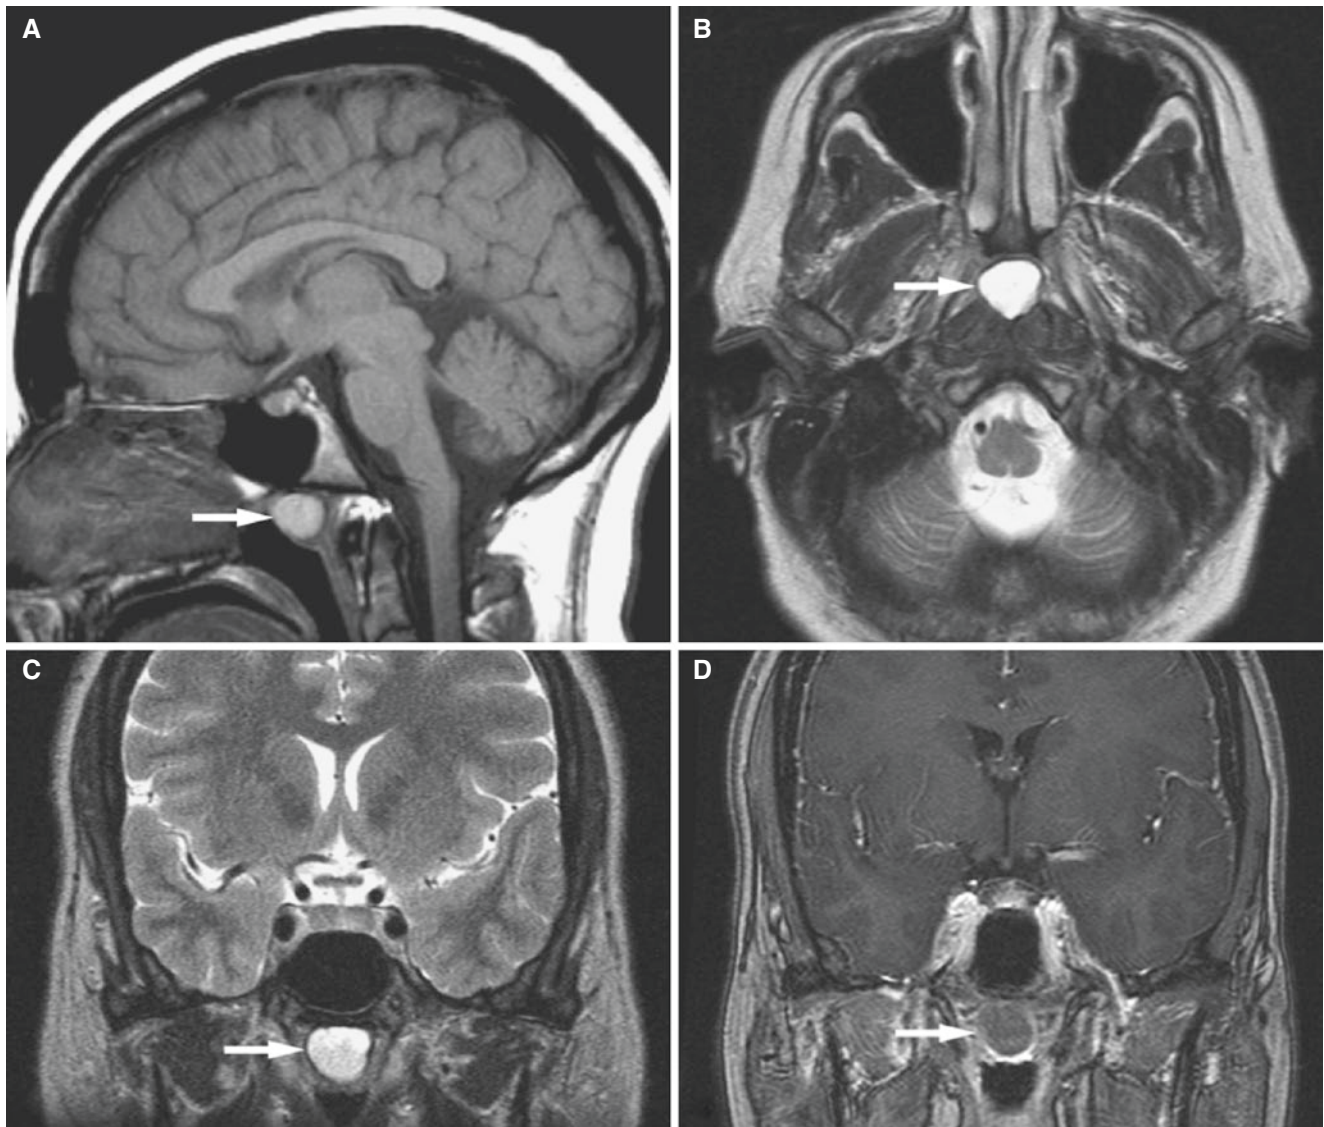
Tornwaldt's cyst, large; incidental findings in a 30-year-old. (A) Sagittal T1-weighted MRI shows low-signal cyst (*arrow*) in posterior nasopharynx. (B) Axial T2-weighted MRI shows bright signal
